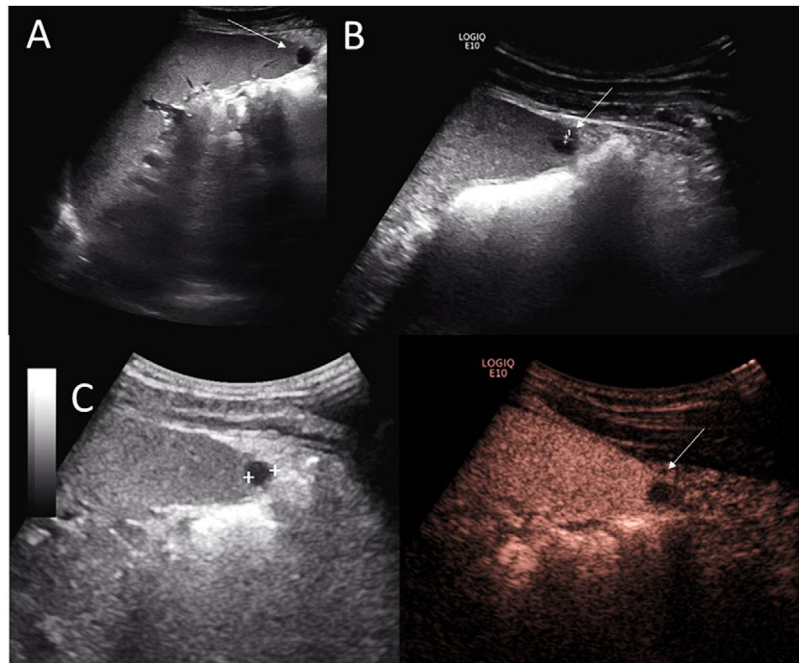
50-year-old male who attended for routine ultrasound. (A and B) Baseline ultrasound demonstrating a well-demarcated unilocular anechoic millimetre-sized lesion with minimal internal septation (white arrows) and septum (between cursors in B). (C) Contrast-enhanced ultrasound with complete absence of uptake by the lesion and septum (white arrow). Findings compatible with a pseudocyst.
